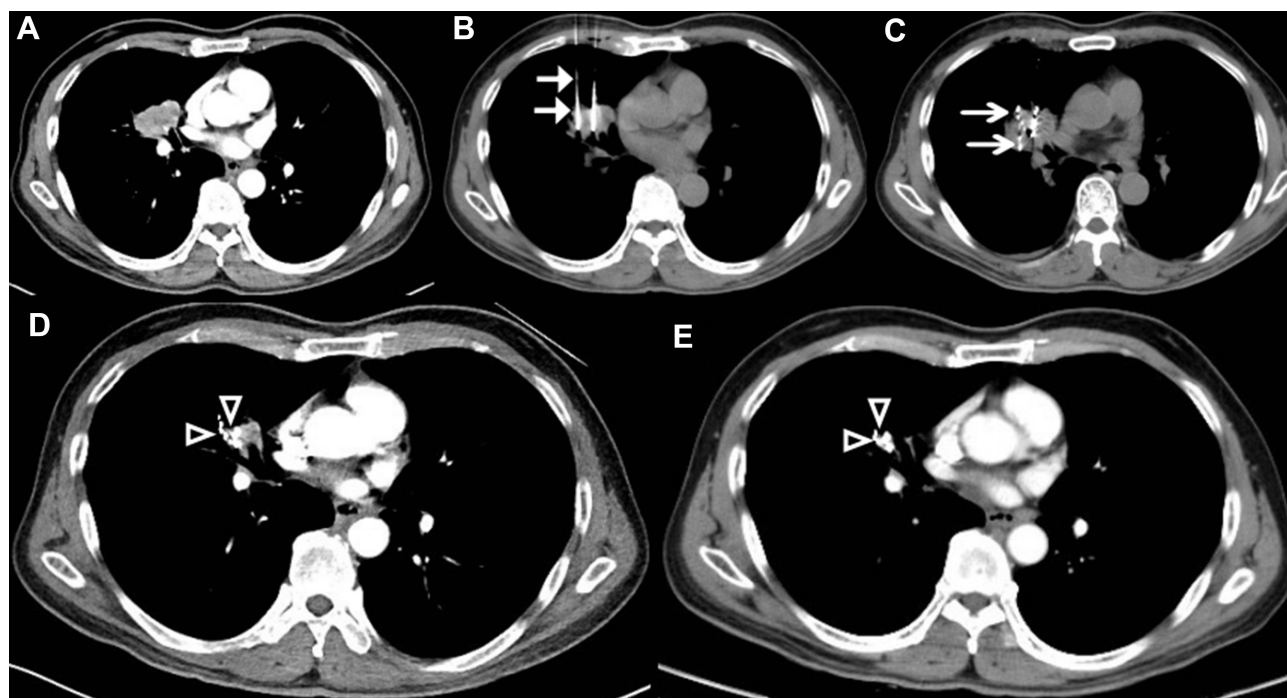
Computed tomography (CT)-guided percutaneous ¹²⁵I seed implantation was performed. (A) CT scan before brachytherapy. (B and C) The procedure of CT-guided ¹²⁵I brachytherapy was performed according to preoperative TPS, 18 G spinal needles were inserted to reach the tumor (arrows), seeds were released from deep to shallow (arrows). (D) One month after treatment, the lesion apparently shrunk (arrows). (E) Six months after treatment, the tumors disappeared, with only seeds remaining (arrows).
